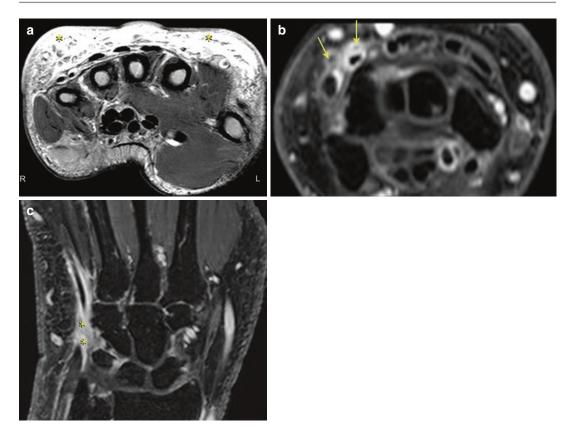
(a) Soft tissue oedema on T1-weighted MRI; (b) tenosynovitis of extensor pollicis brevis and abductor pollicis longus (*arrows*) and (c) synovitis around extensor
